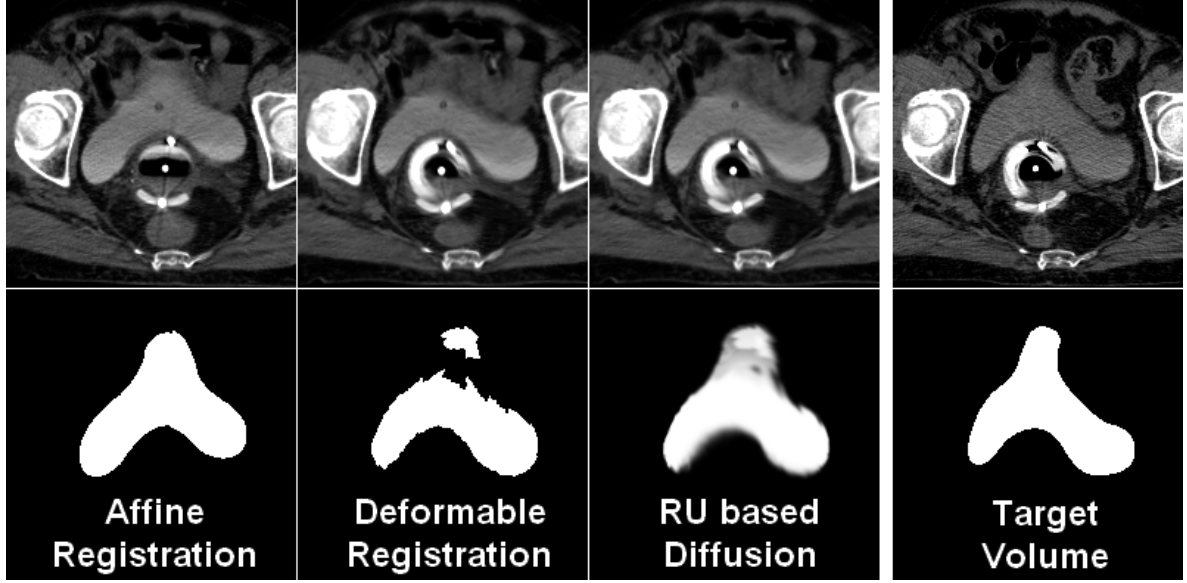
Qualitative effects of DIR and RU based diffusion on segmentation labels of the entire bladder. Exemplar slice of corresponding moving and target CT volumes (top) and segmented bladder (bottom) depicting the progressive stages of the intra-patient registration of moving to target image.
